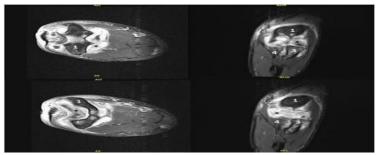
Magnetic resonance imaging scan of the elbow (1, humerus; 2, olecranon; 3, radius; 4, ulnae; \*shows synovial inflammation suggestive of osteomyelitis with suspected septic arthritis)
